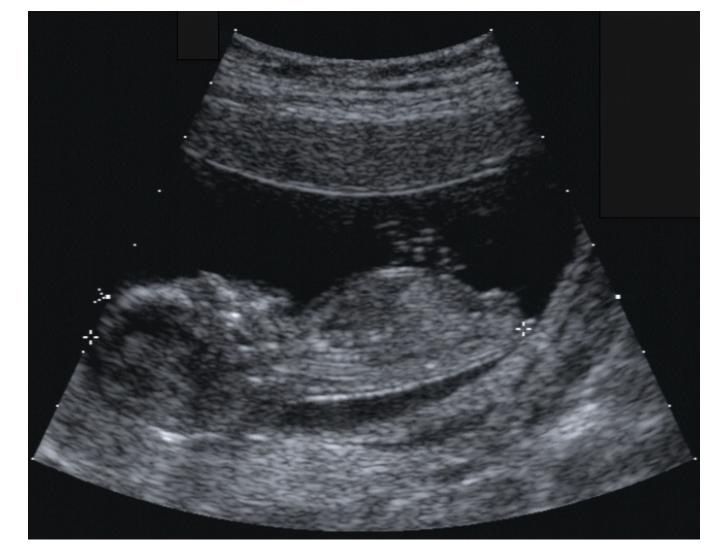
Prenatal ultrasonography showing fetus without limbs
